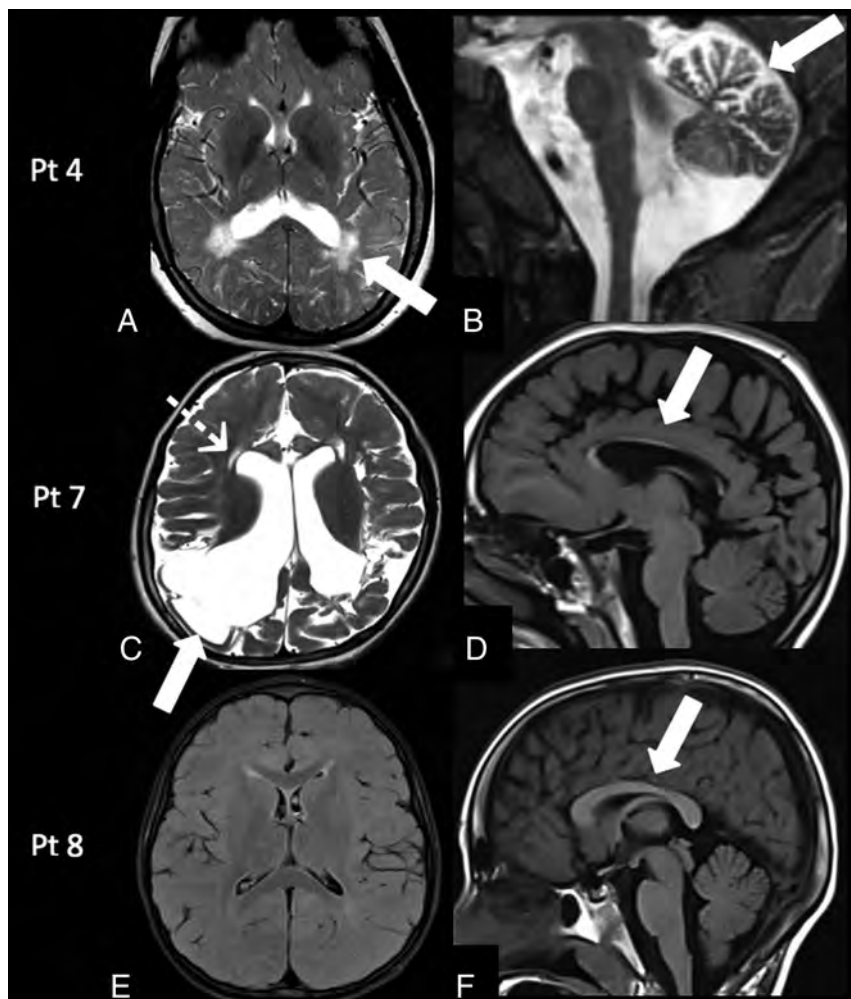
Follow-up MR imaging findings in galactosemia. Patient 4: MR imaging at 13 years of age shows the persistence of the peritrigonal white matter abnormalities on axial T2-weighted image (A, arrow) associated with the presence of mild cerebellar atrophy on sagittal T2-weighted image (B, arrow). Patient 7: MR imaging at 5 years of age demonstrates encephalomalacic changes in the bilateral cortical and subcortical parieto-occipital regions on axial T2-weighted image (C, arrow), with ventricular dilation, cystic changes in the periventricular white matter (C, dotted arrow), and corpus callosum thinning on a sagittal T1-weighted image (D, arrow). Patient 8: MR imaging at 7 years of age demonstrates persistently delayed myelination on an axial FLAIR image (E) and a normal corpus callosum (F, arrow). Pt indicates patient.
